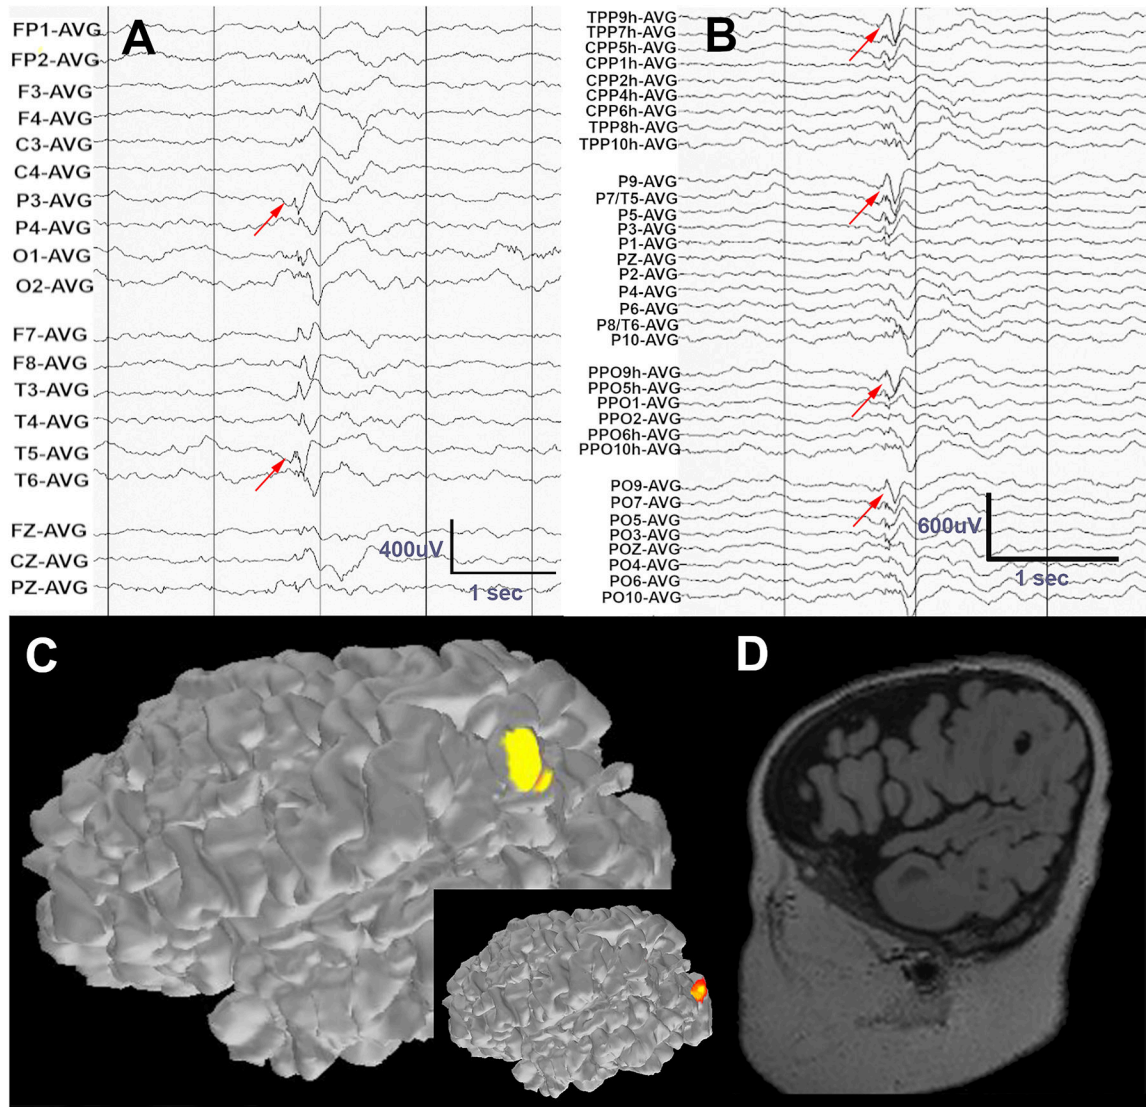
A) Standard LD-EEG recording of an epileptic spasm shows a complex event with possible first negative deflection at T3 and P3 (red arrows). B) On visual analysis of HD-EEG channels, a leading spike in left parietooccipital region is clearly evident and consistent across adjacent channels. C) ESI of the leading spike localizes to the left posterior parieto-occipital region using HD-EEG data. ESI based on LD-EEG (inset) localizes this event to the occipital cortex. D) MRI in this patient revealed a cyst-like cortical tuber that co-localizes with the HD-EEG ESI estimate of the ictal event. The data were band pass filtered at 1–70Hz, with a notch filter at 60Hz.
